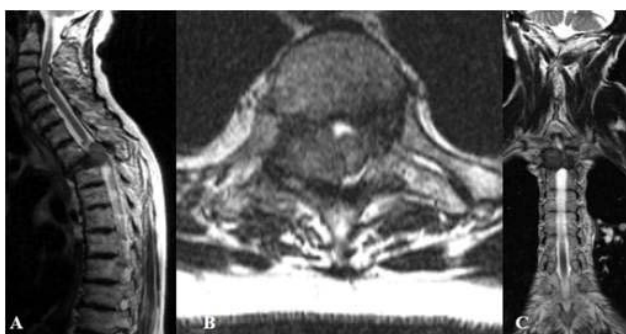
T2-weighted MRI (A-C) in a patient with extradural and intradural atypical thoracic meningioma at T2-T3 level infiltrating the right pedicle of Th2 vertebra.
